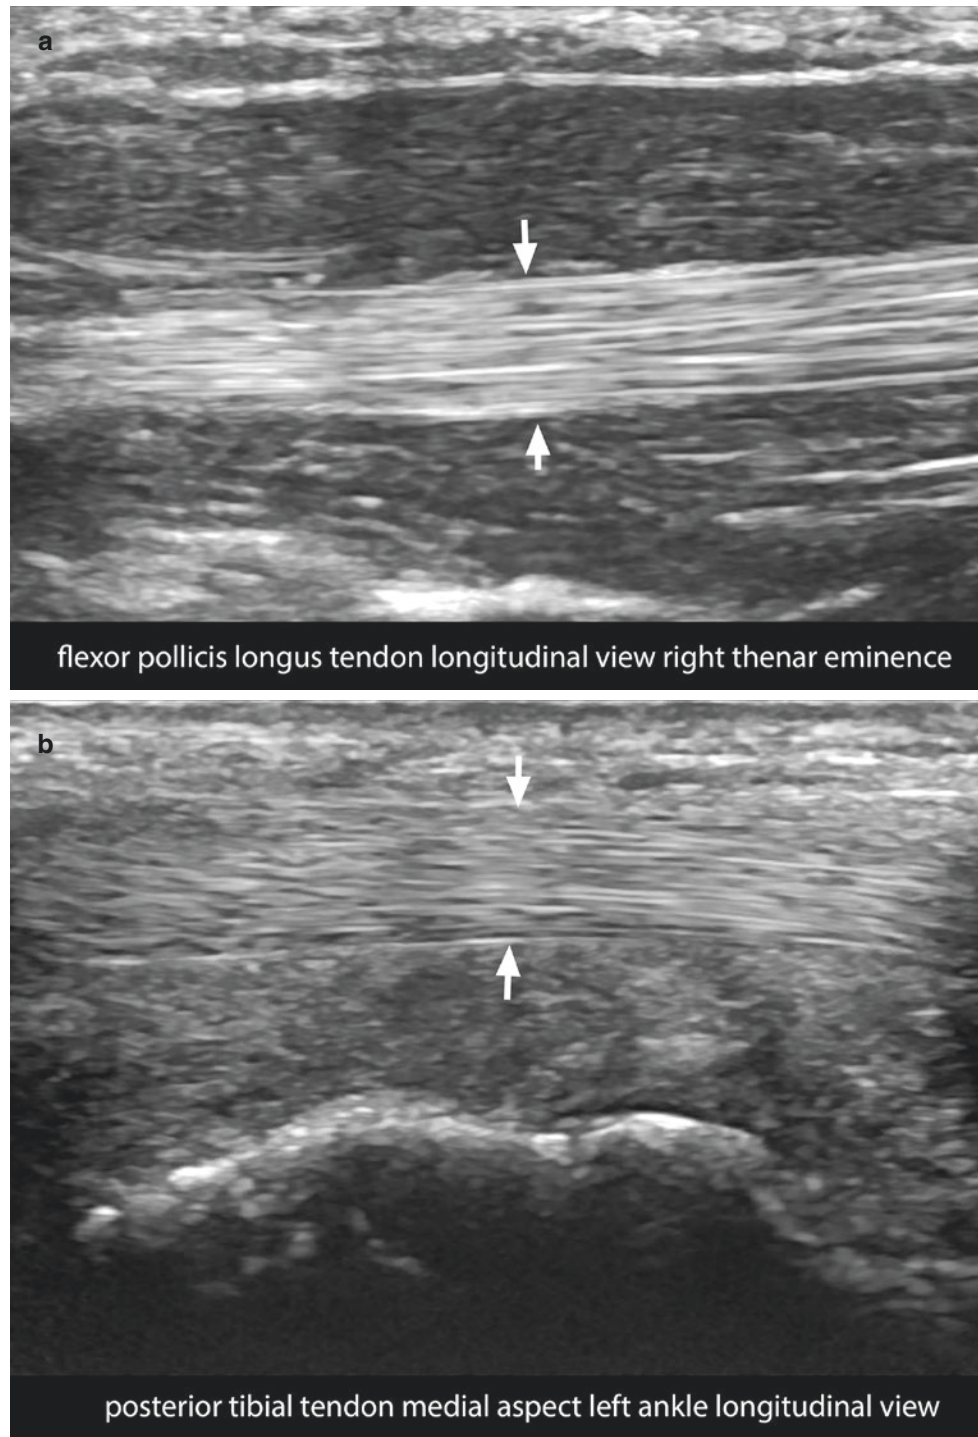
Normal ultrasound morphology of the tendons. (a) Flexor pollicis longus. (b) Posterior tibial tendon. Notice the hyperechoic fibrillary pattern of the tendons (*arrows*).
